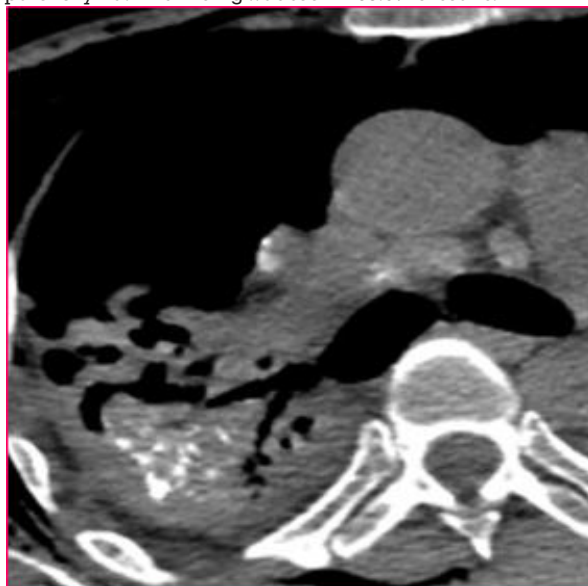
Axial CT thorax mediastinal window showing multiple tiny calcific granulomas in lung parenchyma & fibro-calcific changes (23.1%)
